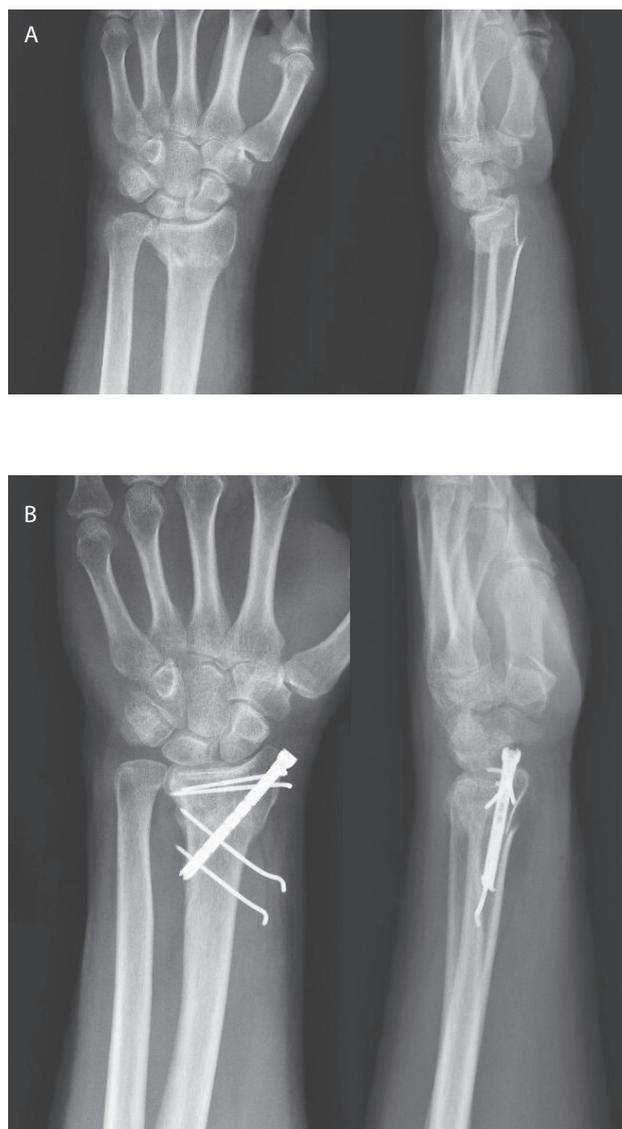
A type A3 fracture of the distal radius. Postero-anterior and lateral radiographs of the fracture (patient B.N.) A) after injury; B) at 3 months after intramedullary X-screw fixation.
